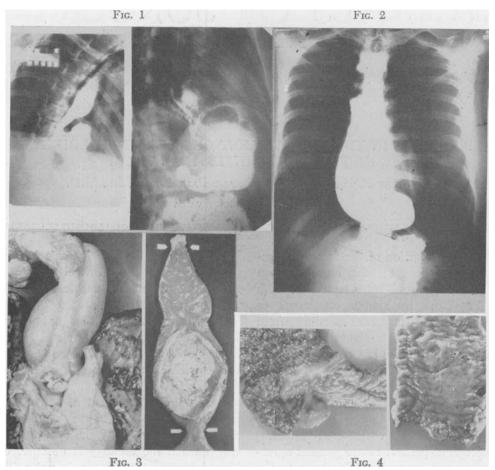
Roentgenograms showing large esophageal hiatus hernia in a female having recurrent bouts of gastro-intestinal bleeding.
